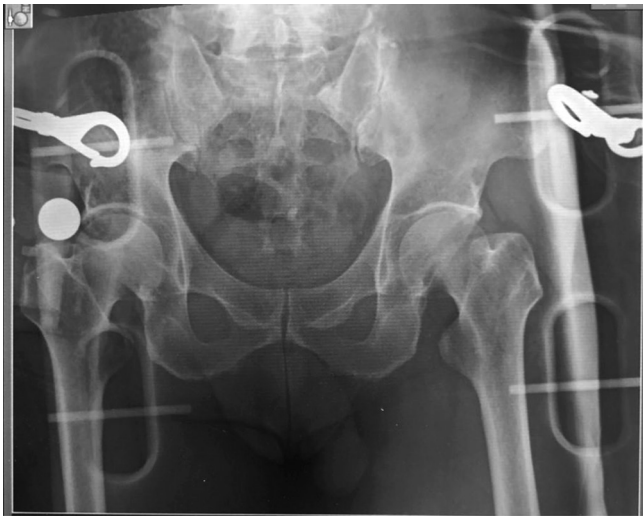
A portable pelvic X-ray image of the present case. The X-ray revealed no abnormalities.
